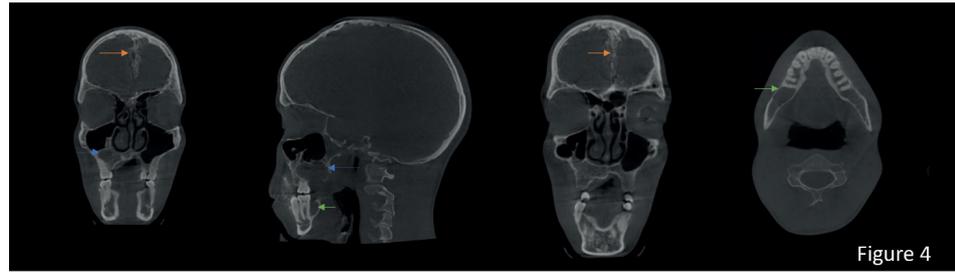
CBCT in 2021 indicating calcification of the falx cerebri (orange arrow), maxillary (blue arrow) and mandibular cystic lesions (green arrow).
